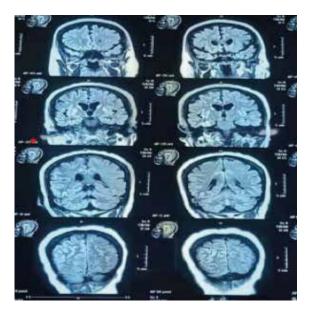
T2 FLAIR showed hyperintensity in bilateral basal ganglia particularly evident in caudate and putamen nuclei along with dorsomedial thalami (pulvinar nucleus), multifocal hyperintense cortical patches with more generalized involvement in the right cerebrum.
